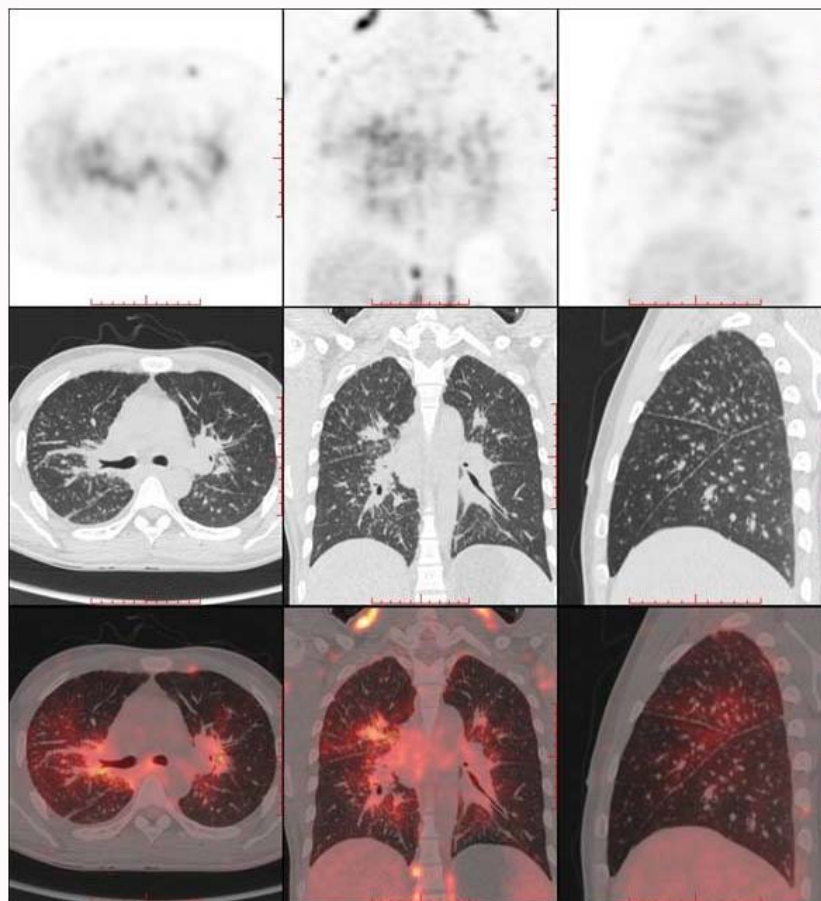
^{18}F -FDG PET/CT in a 25-year-old male with systemic TB: Miliary nodules in both lungs (SUVmax=2.2-12.8).
